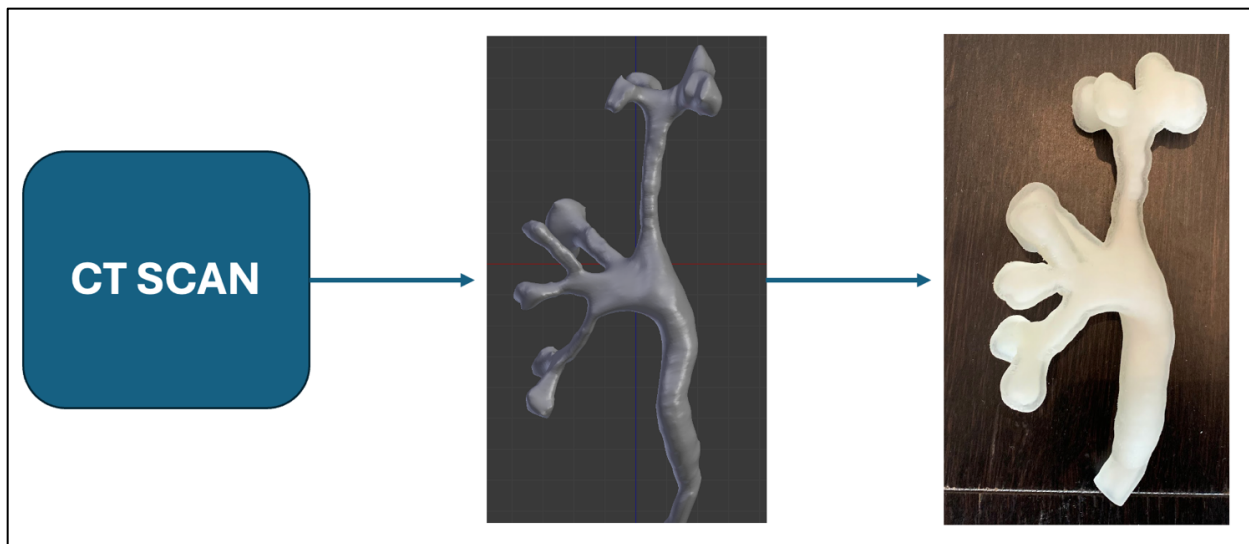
Our 3D-printed kidney model based off patient CT scan.
